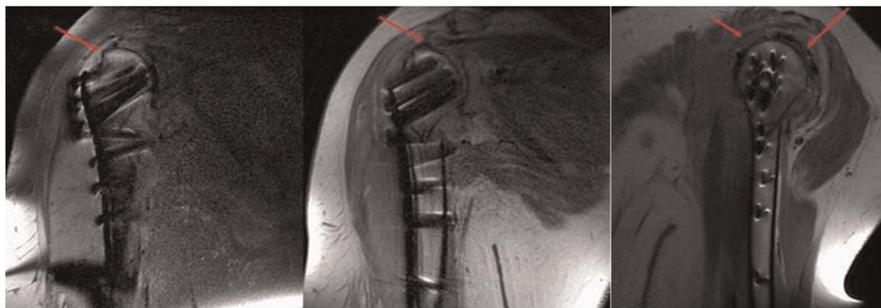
Example of MRI after surgical fixation of proximal humerus fracture using CFR-PEEK proximal humerus plate and screw. Arrows demonstrate a complete rotator cuff tear with retraction (figures courtesy of Bruce Ziran, MD).
